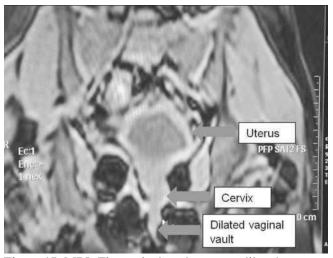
MRI: The vaginal vault appears dilated up to the cervix and uterus.
